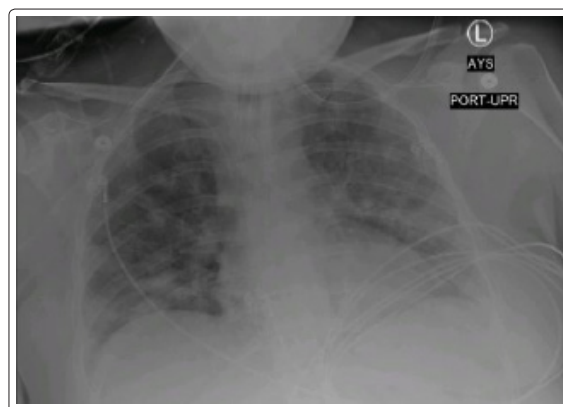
Chest radiograph prior to discharge
